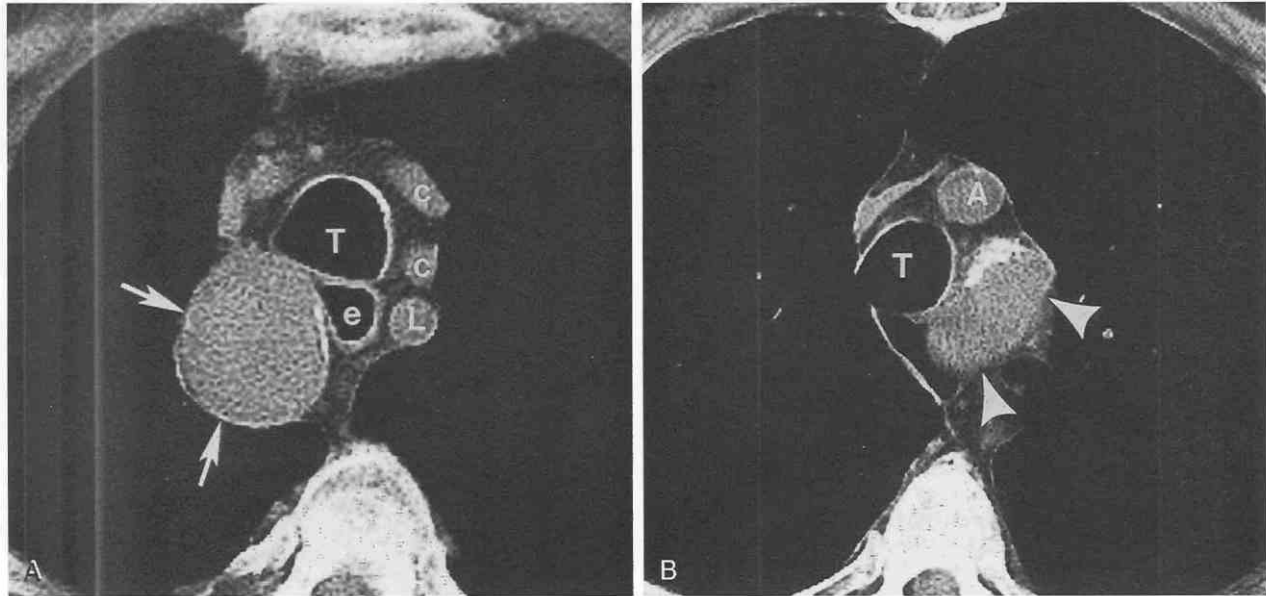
Aneurysm of aberrant right subclavian artery. *A*, CT shows homogeneous soft tissue mass (arrows) with rim calcification posterior to the trachea (T). *B*, A more caudal CT image confirmed that the mass is an aneurysm of the aberrant right subclavian artery, originating from the proximal descending aorta (arrowheads). A, common origin of carotid arteries from aorta; c, left and right common carotid arteries; e, esophagus; L, left subclavian artery.
